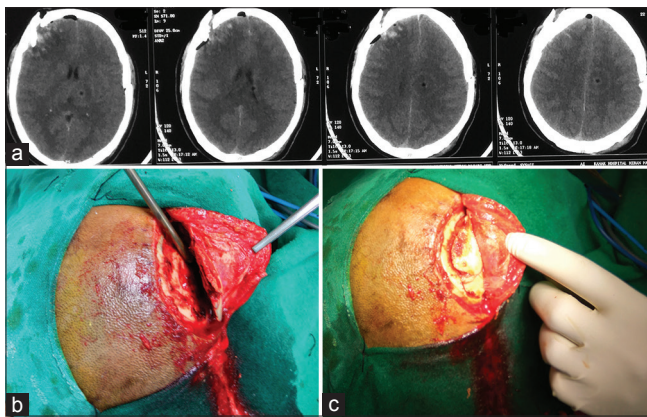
(a) Noncontrast Computed Tomography head showing elevated right frontal bone fracture, (b) intraoperative image showing elevated fracture, (c) intraoperative image after reduction of elevated fracture
